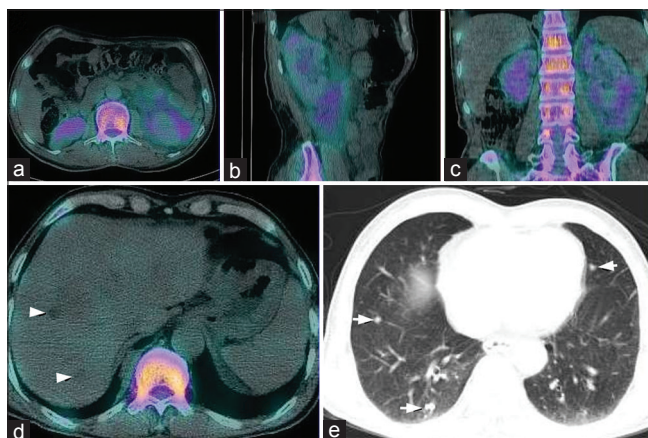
Single photon emission computed tomography-computed tomography of the abdomen shows perirenal collection of tracer activity in orthogonal views (a -axial, b - sagittal, c - coronal) consistent with perirenal leak. In addition, non tracer-avid hepatic (d) and pulmonary lesions (e) are detected on computed tomography
